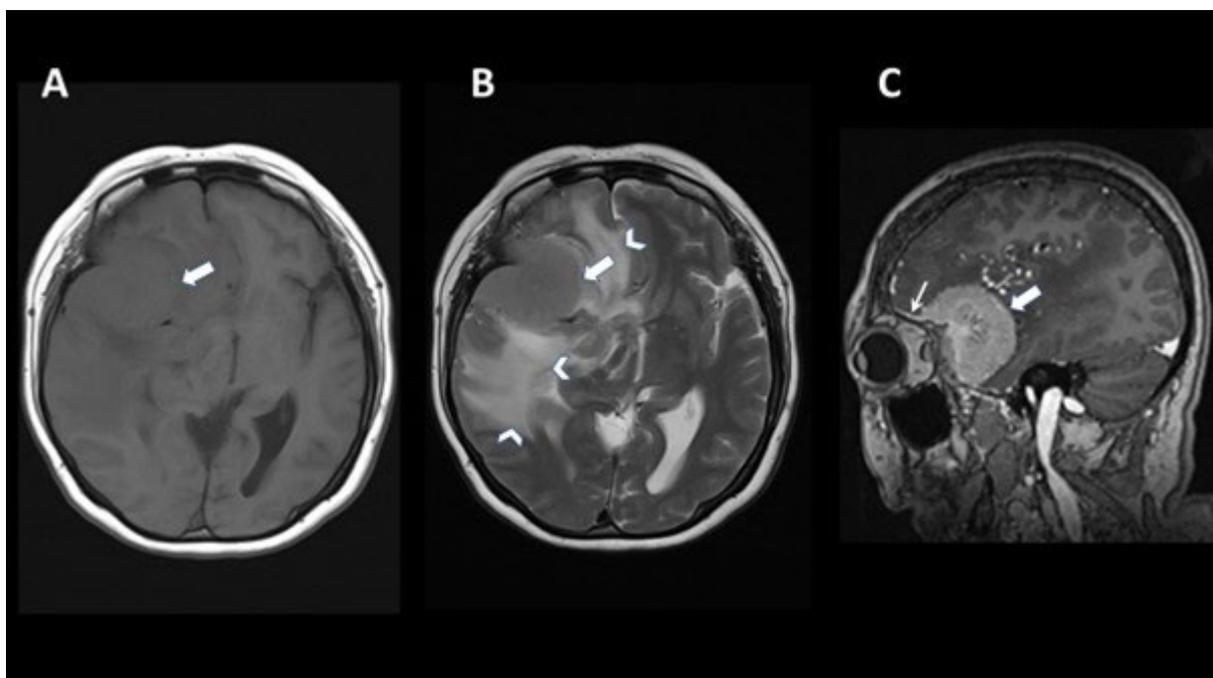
A contrast enhanced MRI brain of the same patient showed an extra-axial mass (thick white arrows) in the right frontoparietal region. It was isointense to the grey matter on axial T1WI (Figure 2A), slightly hyperintense to grey matter on axial T2WI (Figure 2B) and demonstrated avid enhancement post gadolinium on sagittal view (Figure 2C) with a distinct dural tail (thin white arrow). There was mass effect and significant midline shift to the left with perilesional white matter oedema (arrow heads).
